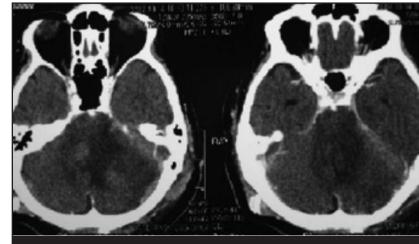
CT brain 4 days after the onset of deterioration shows worsening oedema of the brainstem and cerebellum.
